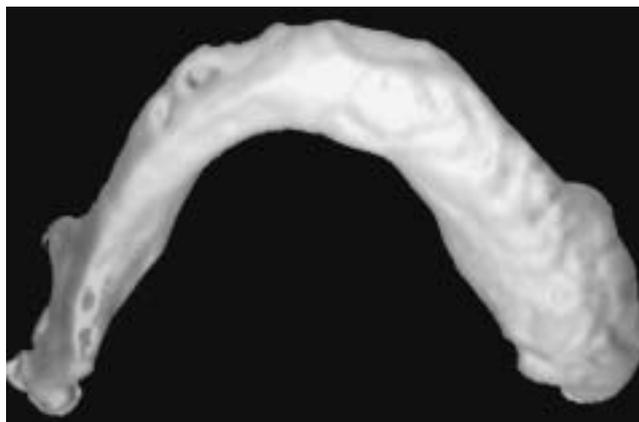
CT axial projection with 3-D reconstruction at the same level as in *Figure 1* demonstrated marked thickening of the angle of the mandible from periosteal reaction (arrow).
